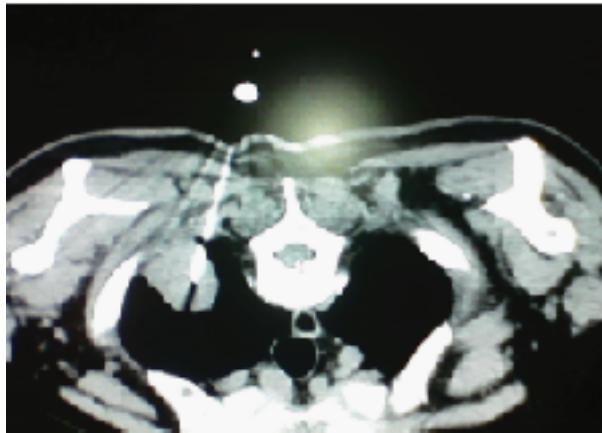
CT-guided FNAC from lung lesion.
